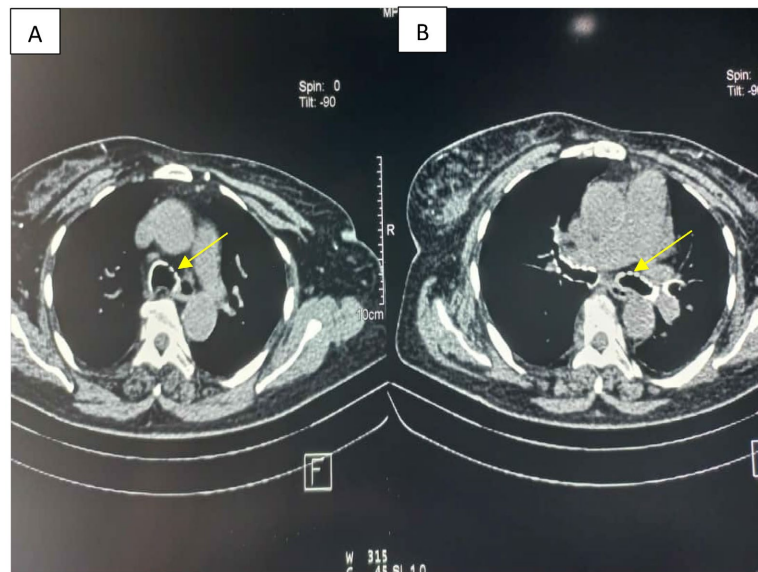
Thoracic CT scan showing calcified nodules of the thickened tracheobronchial tree bordering the anterolateral wall on images (A) and (B) (yellow arrows).
